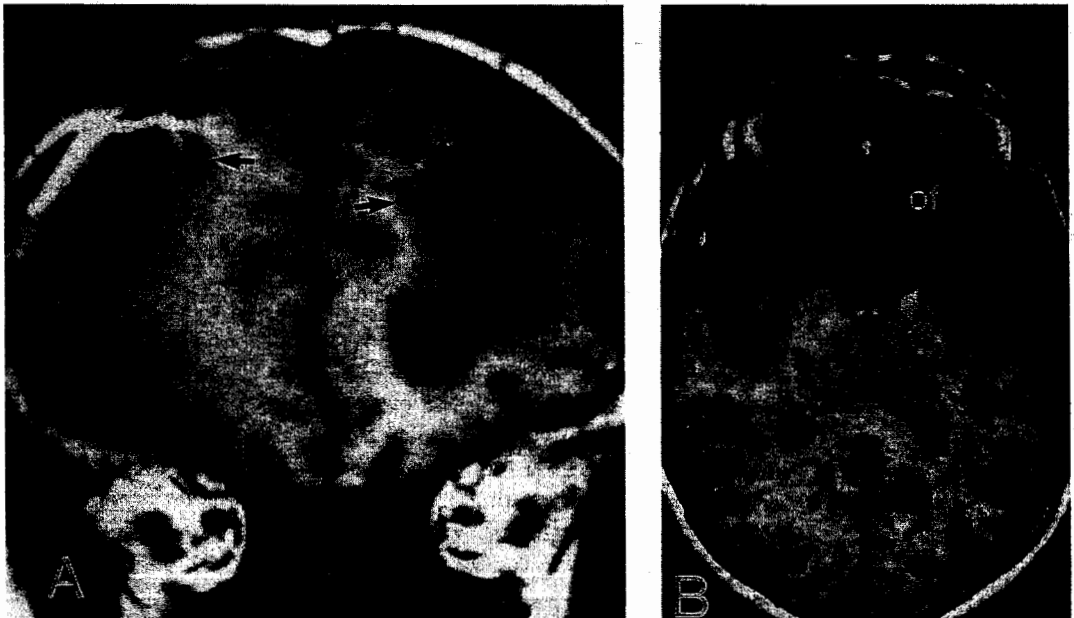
Magnetic resonance imaging scans of two patients. A: Coronal section through the anterior frontal lobe. The lesions (arrows) are predominantly in the heteromodal component of prefrontal cortex. B: Horizontal
